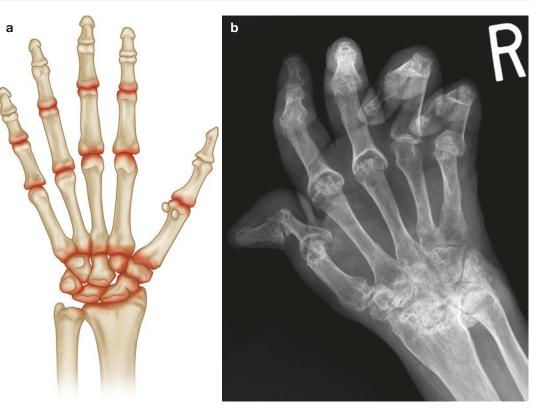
(a) Common sites of involvement with rheumatoid arthritis. (b) PA radiograph of right hand with changes of long-standing rheumatoid arthritis (similar changes were noted in the left hand and wrist in keeping with symmetrical disease). Marked diffuse osteopenia, extensive
